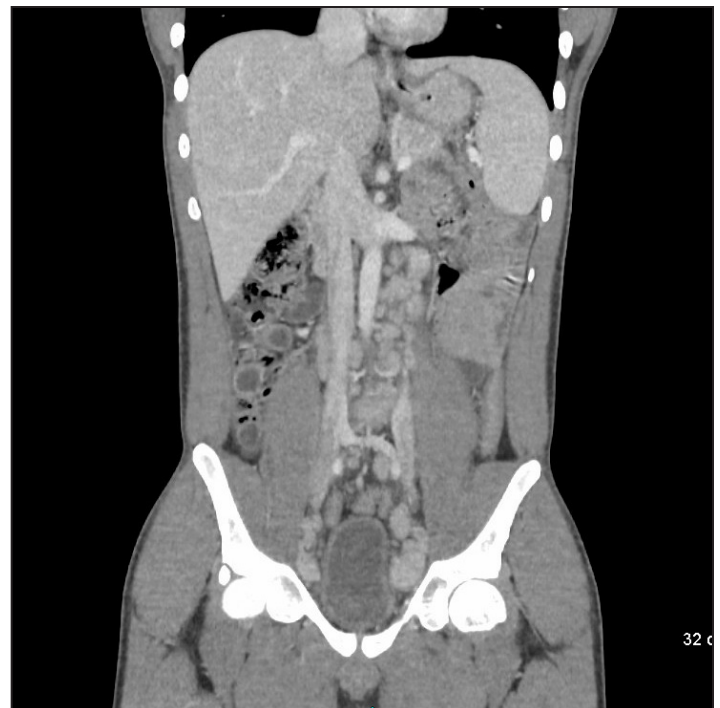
CT abdomen and pelvis with IV contrast showing extensive lymphadenopathy involving inguinal, iliac chain, retroperitoneal and retrocrural nodal stations. The largest lymph node in the left superficial inguinal region displays central hypodense areas likely secondary to necrosis. This lymph node measures approximately 4.1 x 2.8 cm in greatest axial dimensions.
